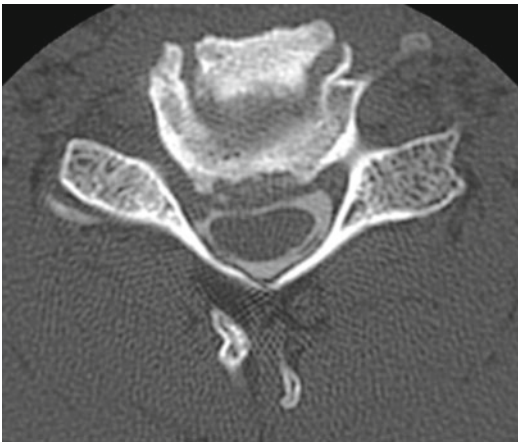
Axial postmyelogram computed tomography scans an uncovertebral spur on the right. The axial slice cuts obliquely through the disk space and through the foramen on the right
